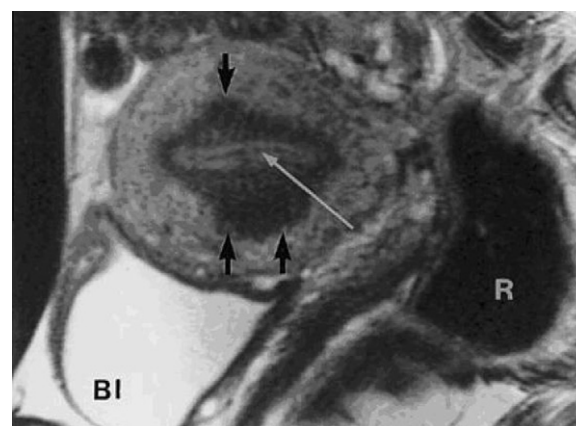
Adenomyosis as identified through focal thickening of the myometrial junctional zone (JZ). Sagittal T2-weighted magnetic resonance image demonstrates focal thickening of the JZ (short arrows) both ventrally and dorsally, consistent with adenomyosis. Although the maximal thickening of the JZ ventrally was <12 mm, the focal nature of the thickening suggests adenomyosis. Note the absence of mass effect on the endometrial cavity. The linear area of low signal within the endometrial cavity (long arrow) represents menstrual blood. Bl = bladder; R = rectum.
